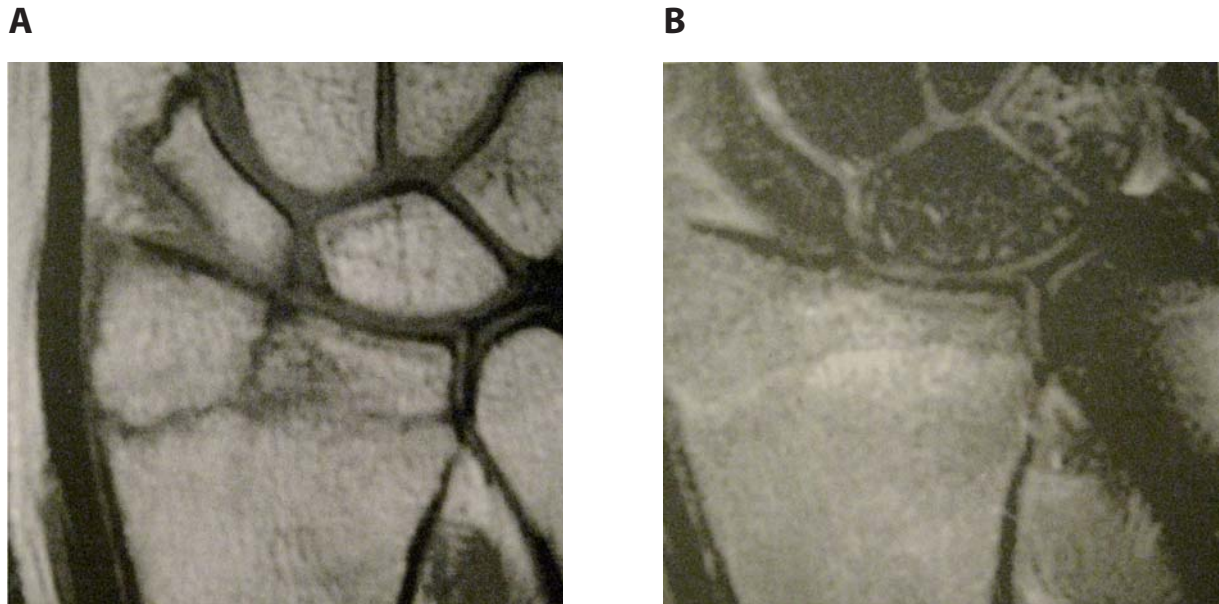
An MRI scan of an intra-articular fracture of the radius: the fracture line in the T1-weighted sequence (A) and a hyperintense area of bone marrow edema in the T2-FSE sequence (B).
